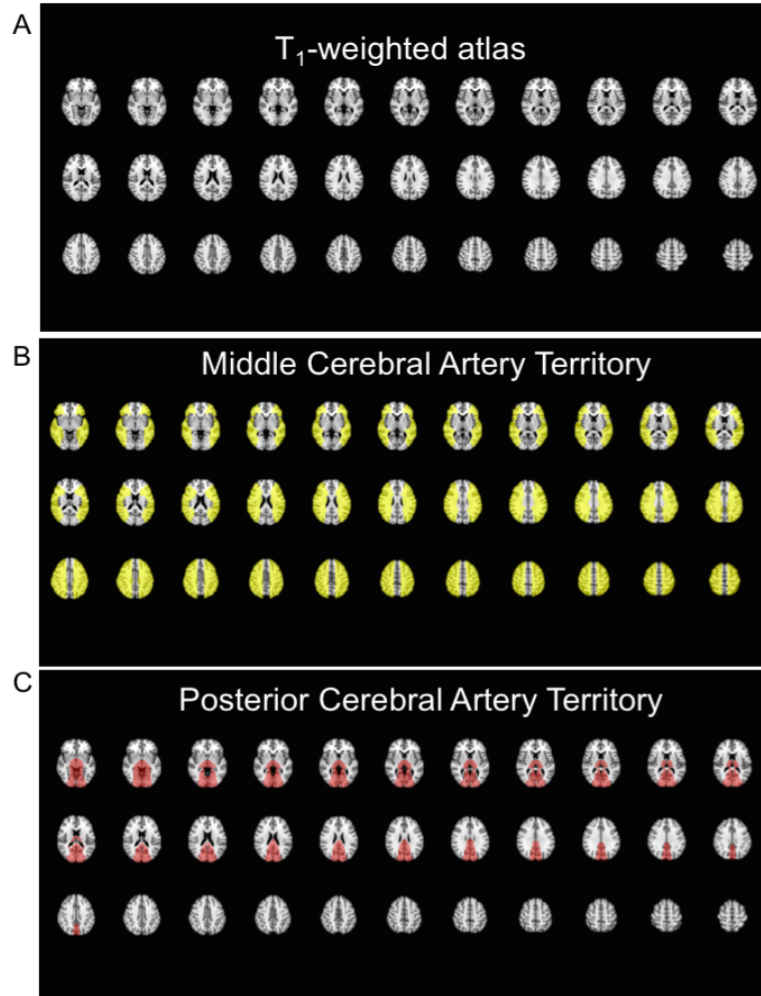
ROIs used for compliance measures. A T_1 -weighted atlas is shown in (A). Middle cerebral artery (MCA) and posterior cerebral artery territory were determined by including all tissue in the area of corresponding MCA Alberta Stroke Programme early CT score regions. Axial slices with overlaid territory map for the MCA and posterior cerebral artery territory are shown in (B) and (C), respectively.
